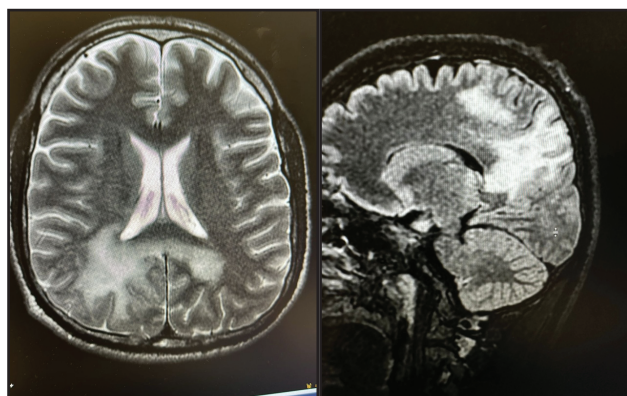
Cranio-cerebral MRI scans with contrast. Transverse and sagittal planes are shown.
